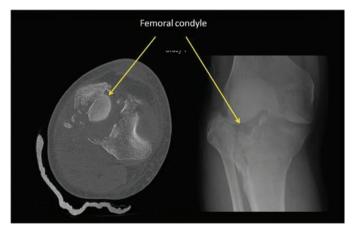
CT scan of tibial plateau fracture showing severe depression of the lateral tibial plateau, caused by the lateral femoral condyle driving through the lateral tibial plateau
